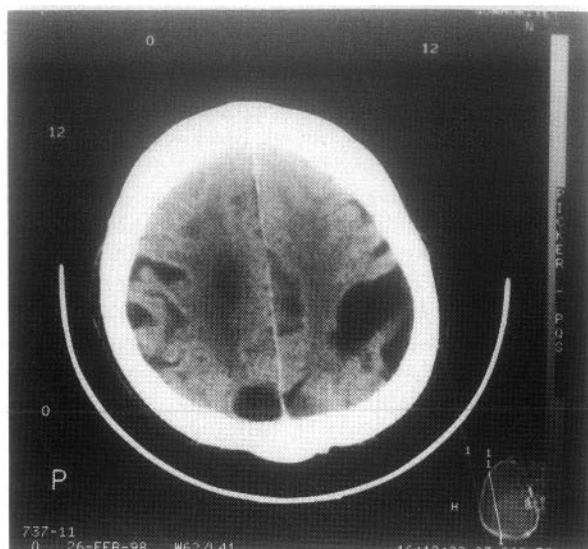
CT showing multiple infarct areas
